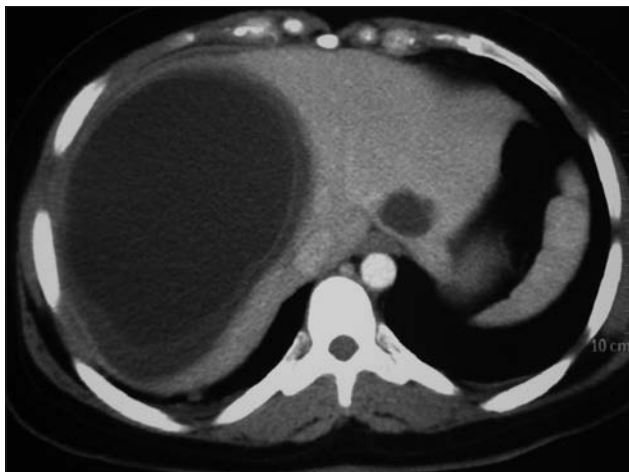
Computed tomography scan demonstrating large homogenous liver cyst
